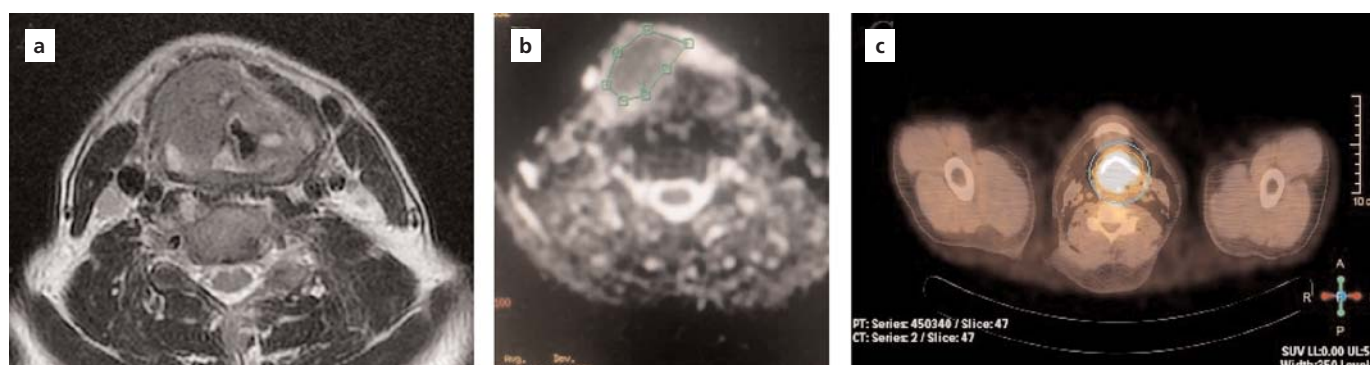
Pretreatment MRI and PET/CT imaging of a case with advanced-stage laryngeal cancer. (a) Axial T2 weighted turbo spin echo imaging (TR/TE 4700/85), (b) ADC map showing laryngeal tumor with extralaryngeal extension, and (c) axial PET-CT demonstrated high SUV at the larynx. [Color figure can be viewed in the online issue, which is available at www.entupdates.org]
